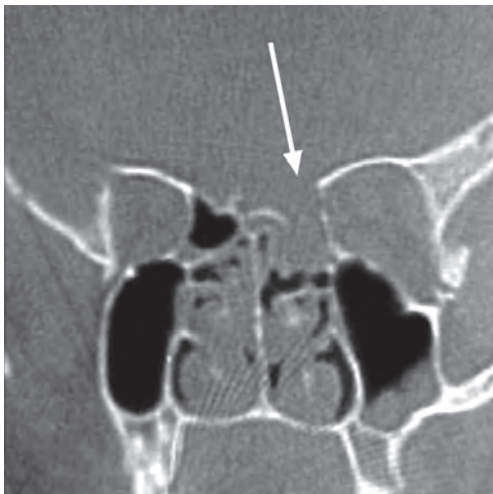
CT bone cuts coronal views showing injury to the cribriform plate
